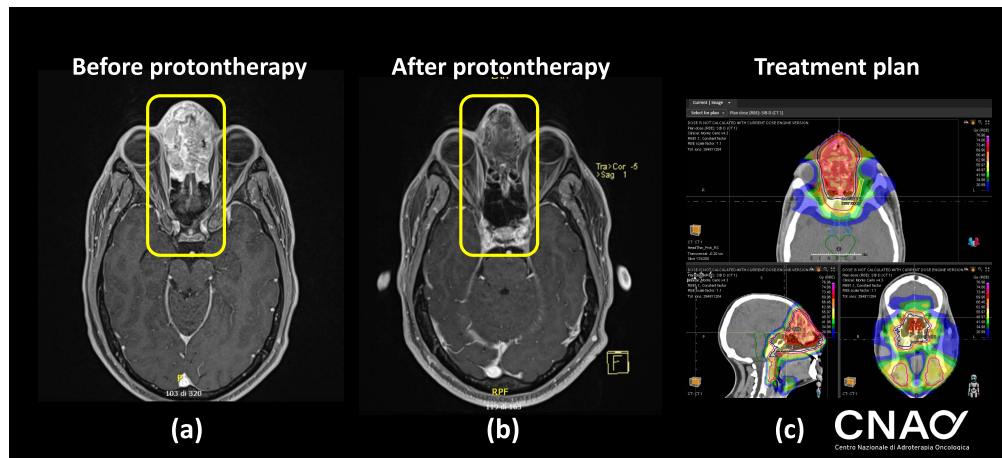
Treatment findings of a patient affected by sinonasal teratocarcinosarcoma treated at CNAO, with a CT slice before (a) and 10 months after (b) treatment with radiosensibilizing chemotherapy and proton therapy. The delivered proton therapy treatment plan is shown in (c), where the red zone corresponds to 70 Gy (RBE) delivered in 33 fractions. Tumor regression can be clearly observed in the tumor region (yellow square). Figure courtesy of V. Vitolo (CNAO).
